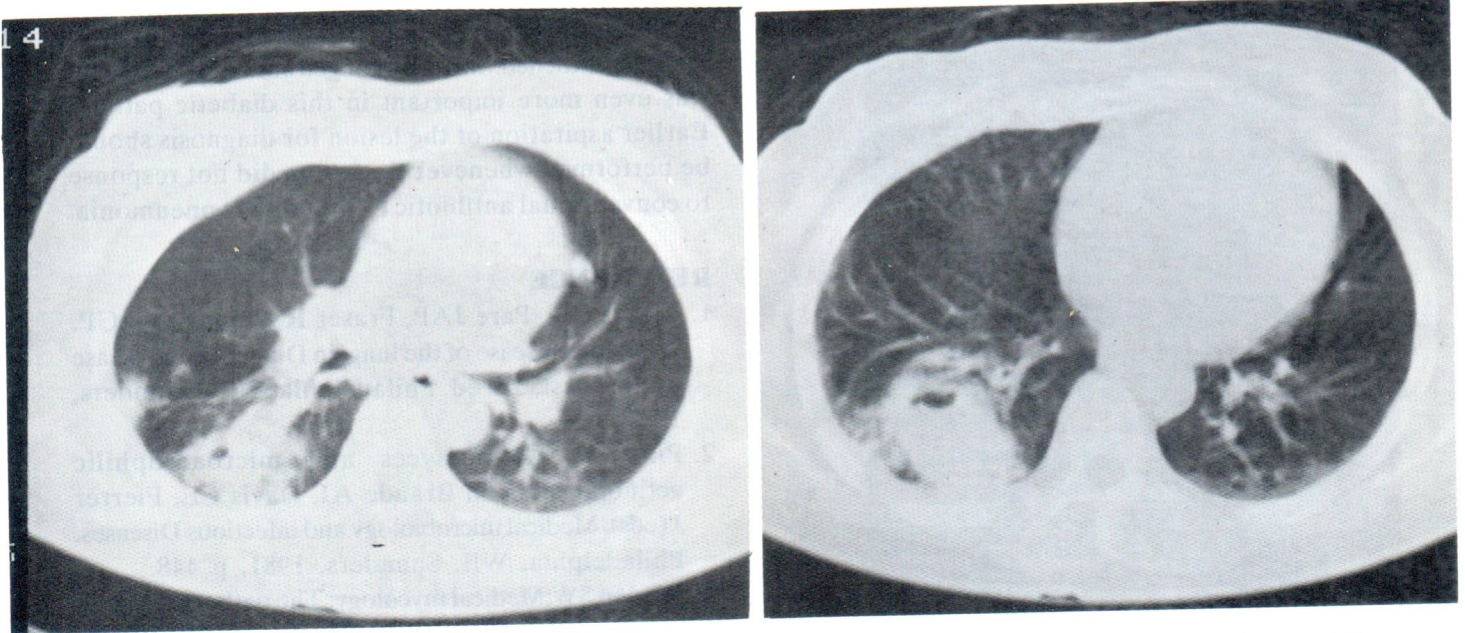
CT scan of the thorax, using lung window showed multiple small alveolar lesions near the mass like lesion.
